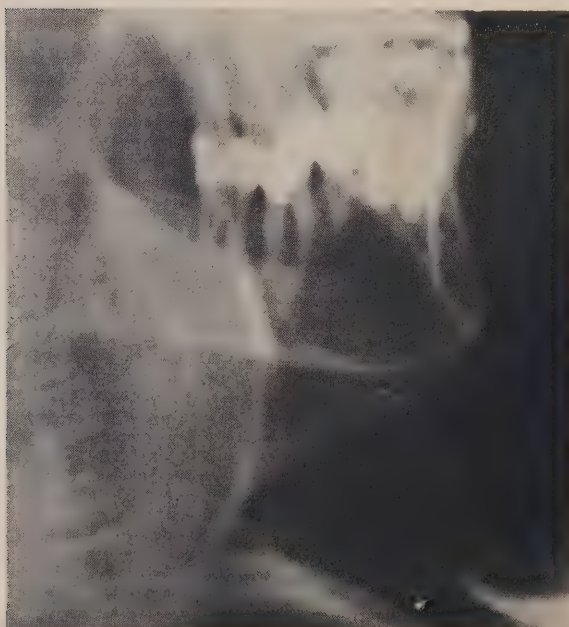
Roentgenogram diagnosed as osteo-fibroma, 1933.
